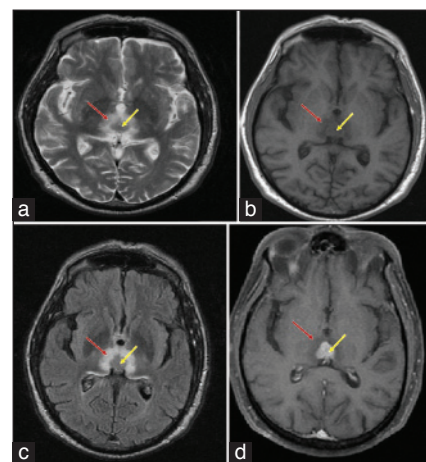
Signal intensity characteristics of the lesion at the mesodiencephalic junction: Isointense on T₂-weighted imaging (T₂WI) (a); isointense on T₁-weighted imaging (T₁WI) (b); isointense on T₂ fluid-attenuated inversion recovery (FLAIR) (c); and homogeneous solid enhancement (d). Yellow arrow points to the lesion and red arrow to the edema surrounding
